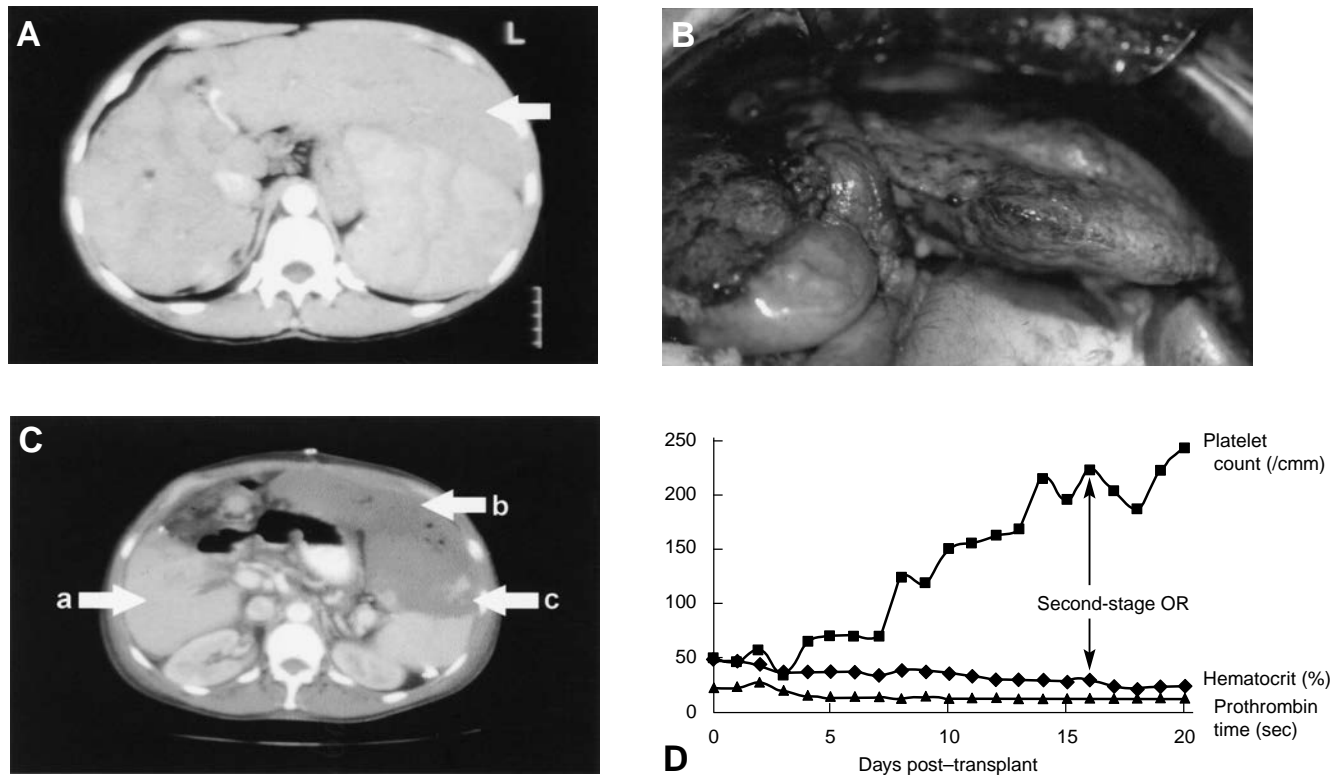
Staging hepatectomy during live-donor liver transplant in a Jehovah's Witness recipient. This 35-year-old male was in end-stage liver failure due to primary sclerosing cholangitis. A preoperative CT scan (A) demonstrates a large left lateral segment of the liver (arrow), which was confirmed at surgery (B). Due to severe hemorrhage from splenic collaterals during hepatectomy, the procedure was staged. A partial hepatectomy was performed. Postoperative CT scan on day 15 (C) showing the transplanted right lobe of the liver (a), the devascularized left lateral segment of the cirrhotic liver (b) and the ischemic upper pole of the spleen (c). Following recovery of the implanted liver and improvement in the hematologic and coagulation parameters (D), the patient was taken back to the operating room for completion hepatectomy and partial splenectomy. The patient had an uncomplicated recovery. (Modified with permission from Jabbour N, Gagandeep S, Mateo R, et al. Live donor liver transplantation: staging hepatectomy in a Jehovah's Witness recipient. *J Hepatobiliary Pancreat Surg.* 2004;11:211–214.
